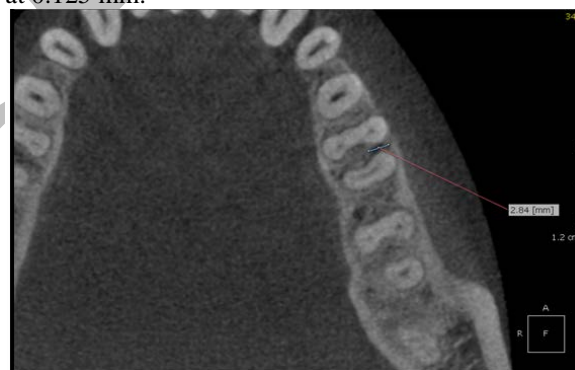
CBCT BL-H measurement
